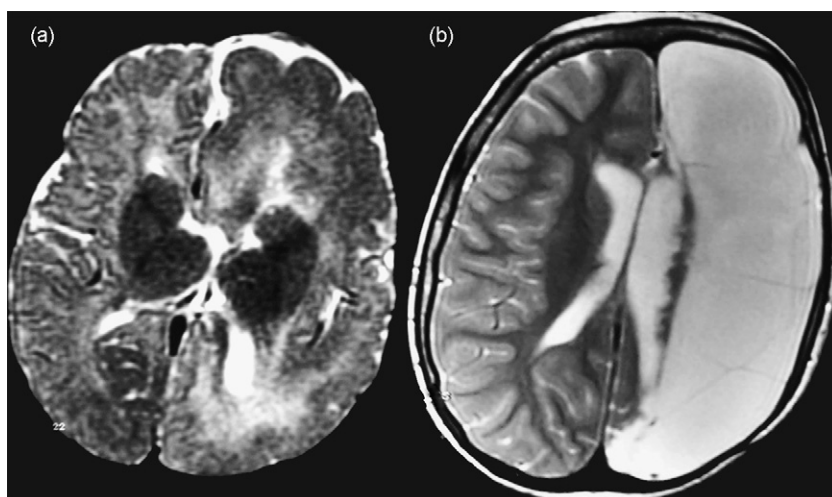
Hemimegalencephaly. (a) Preoperative axial FSE T2w MR image showing hamartomatous overgrowth of the left cerebral hemisphere, mainly due to marked enlargement of hemispheric white matter. The left frontal cortex exhibits an appearance suggestive of polymicrogyria; the lateral ventricle is deformed and distorted. Also note periventricular high signal in the frontal and parietal region resulting from heterotopia and gliosis in the white matter surrounding the enlarged ventricle. (b) Postoperative axial T2w MR image (4 years after anatomical hemispherectomy).
